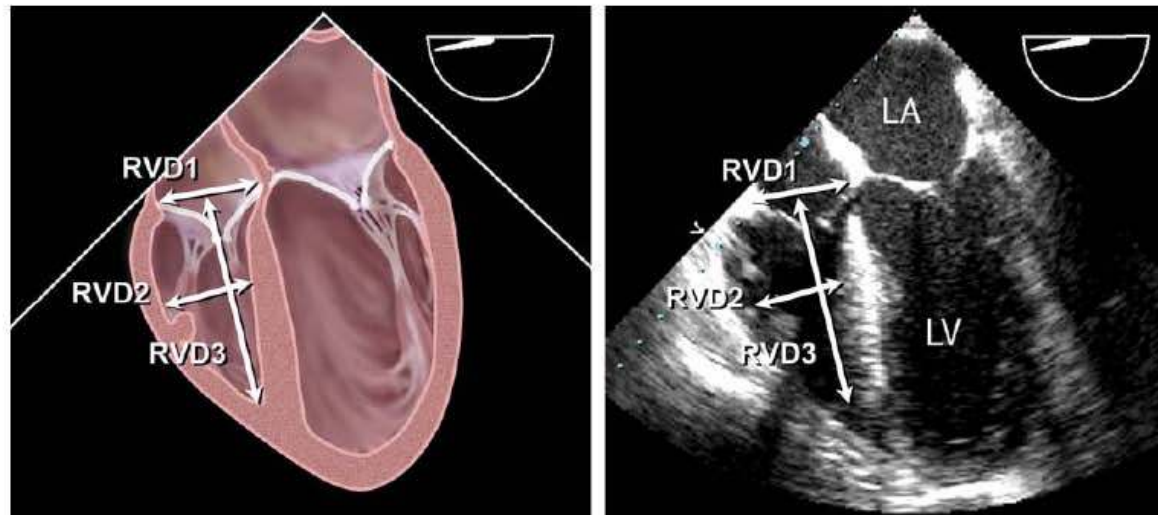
Transesophageal echo measurements of right ventricular diameters from the mid-esophageal four-chamber view, best imaged after optimizing the maximum obtainable RV size by varying angles from approximately 0–20 degrees.
